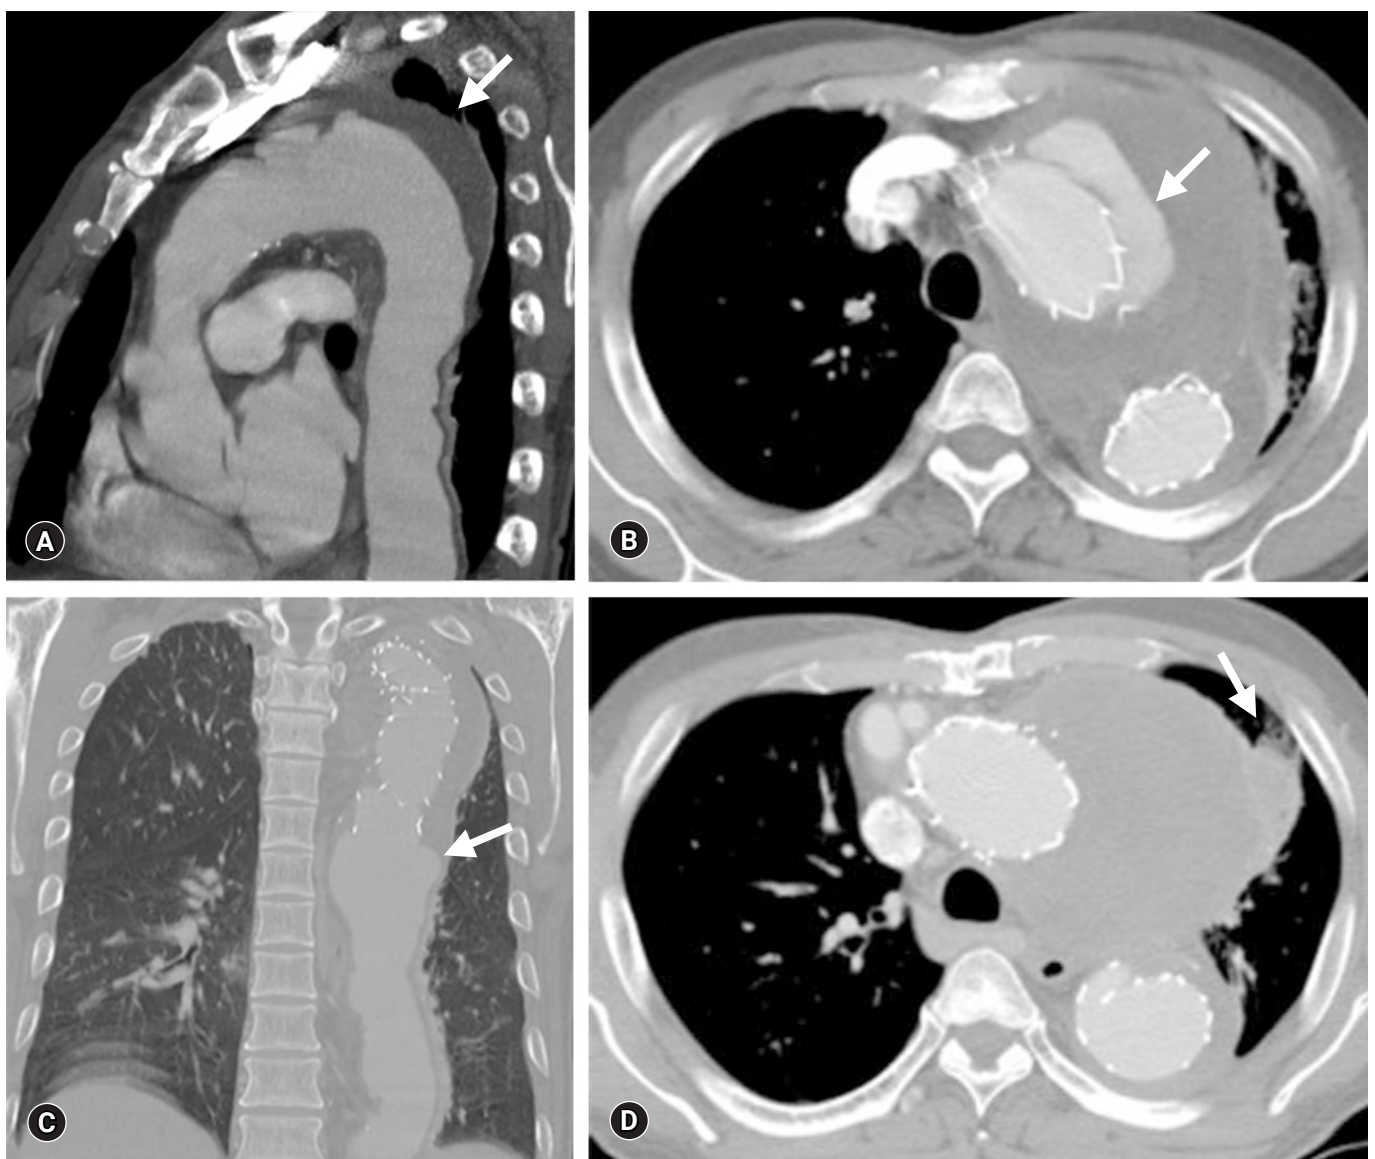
Chest computed tomography (CT) findings. (A) Initial chest CT shows descending aortic pseudoaneurysm (arrow). (B) Two years later, chest CT reveals a newly formed type 1a endoleak (arrow) and an even larger pseudoaneurysm. (C) Chest CT on admission reveals type 1b endoleak (arrow) from the previous stent with progression of the pseudoaneurysm. (D) Lung consolidation with atelectasis (arrow).
